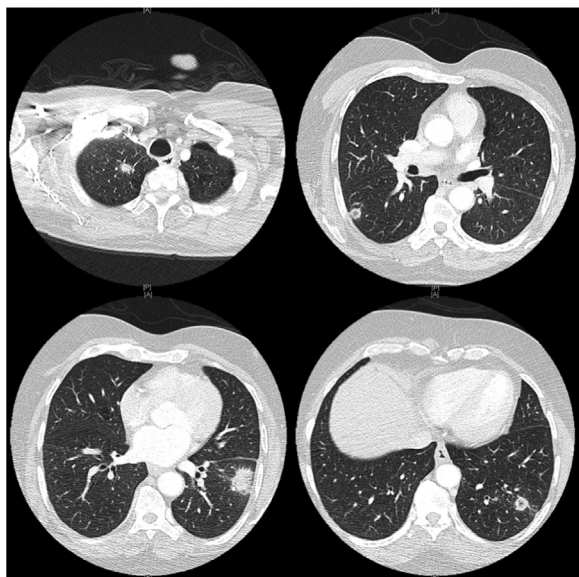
Computed tomography of the chest with iodinated contrast showing multiple bilateral, pre-dominantly subpleural cavitary pulmonary nodules.
